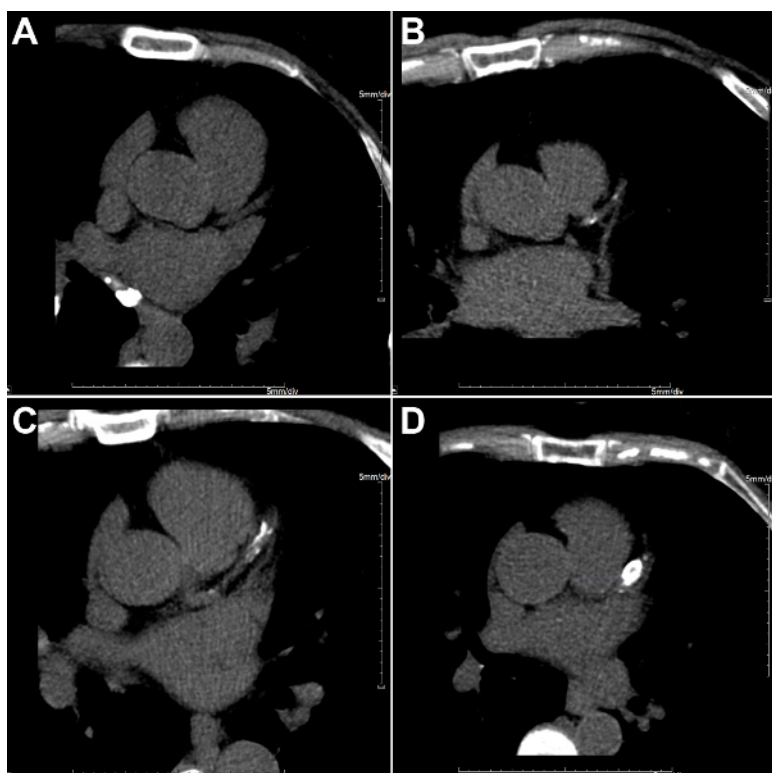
Different degrees of coronary calcification. These panels show axial non-contrast CT chest images of different patients showing (A) no calcification, (B) mild calcification, (C) moderate calcification, (D) and severe calcification of the left anterior descending artery. [Please click here to view a larger version of this figure.](#)
